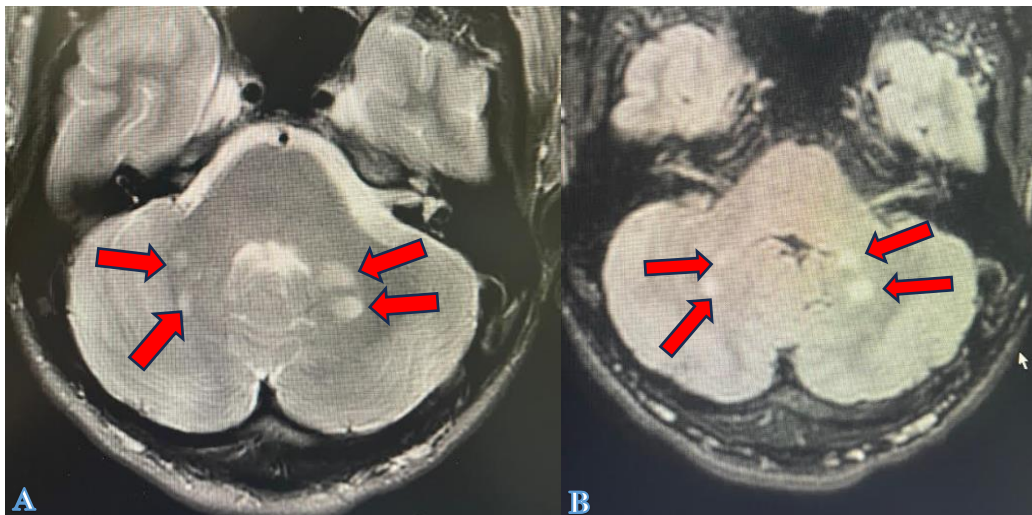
A): Axial T2 MRI; B): Flair; focal areas of altered signal intensity at the infratentorial level with cerebellar localization, compatible with UBO (arrows).
